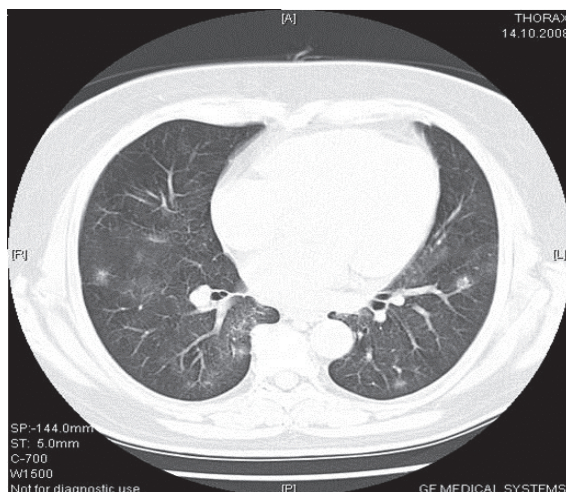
Chest CT scan with signs of interstitial lung disease (patient #3).
